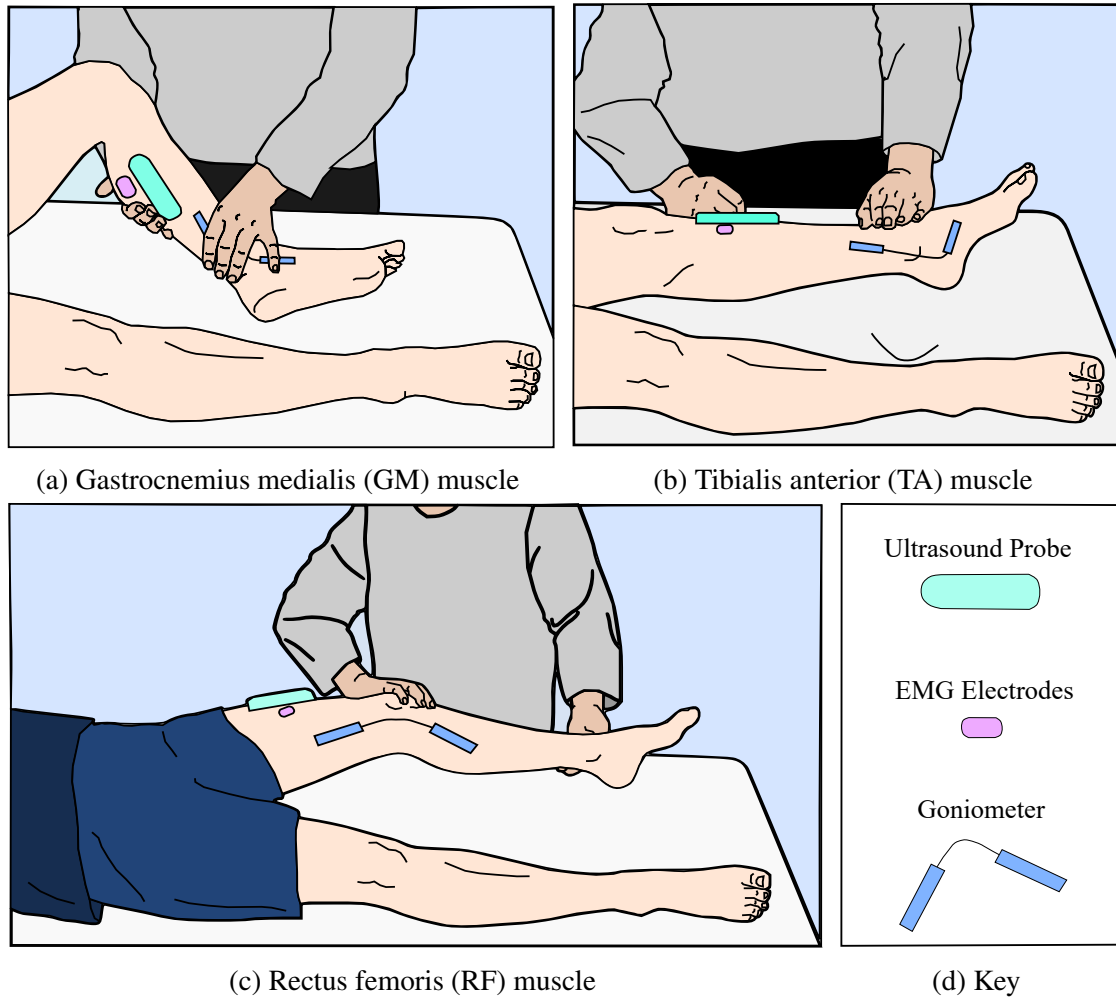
Experimental setup for Study 2 showing the different positions of the participant's leg and the placement of the ultrasound probe, EMG electrodes and goniometer sensors for each muscle. Adapted from [4].
